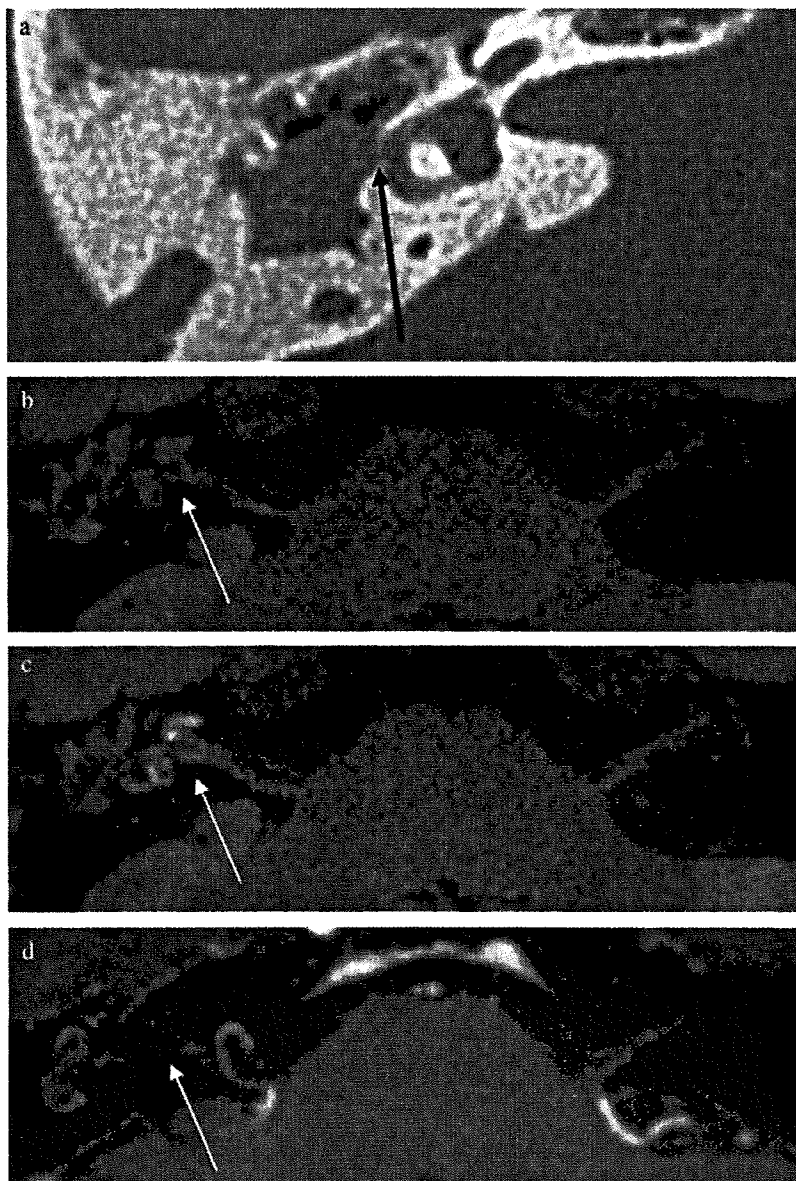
A 58-year-old man with right middle ear cholesteatoma invading the wall of lateral semicircular canal. (a) The CT image shows the erosion of the wall of the lateral semicircular canal by cholesteatoma invasion (arrow). (b) The precontrast 3D-FLAIR image shows the slightly increased signal of the labyrinthine fluid in the right side (arrow) but not in the left side. (c) The post-contrast 3D-FLAIR image reveals marked enhancement in the right labyrinthine fluid (arrow) but not in the left side. (d) The post-contrast 3D T1-weighted image fails to reveal contrast enhancement of the right labyrinthine fluid. These findings show that the increased permeability of the blood-labyrinthine barrier can be visualized by contrast-enhanced 3D-FLAIR images but not by contrast-enhanced T1-weighted images.
